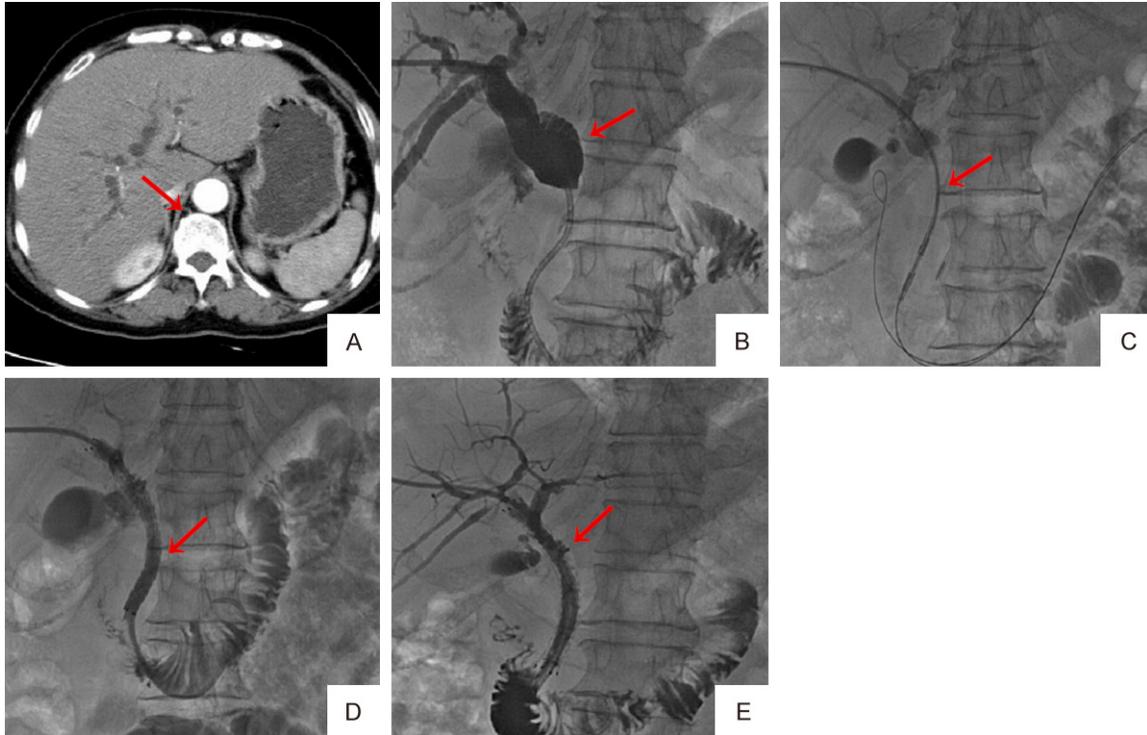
Case study. Note: (A) The arrow showed that the patient had common bile duct dilatation, cholangiocarcinoma complicated with malignant obstructive jaundice by CT examination at admission. (B) The arrow showed that at PTCD cholangiography by puncturing, it found intrahepatic bile duct dilatation, and rhamphoid lower end of the common bile duct. (C) The arrow showed that in PTCD combined with RFA method, the ablation catheter was put along the hard exchanged guide wire to perform radiofrequency ablation in the stricture part of the common bile duct. (D) The arrow showed the implantation of biliary stent. (E) The arrow showed that a metal stent was implanted after balloon dilation, and the cholangiography found well expanded stent and reopen of the common bile duct.
